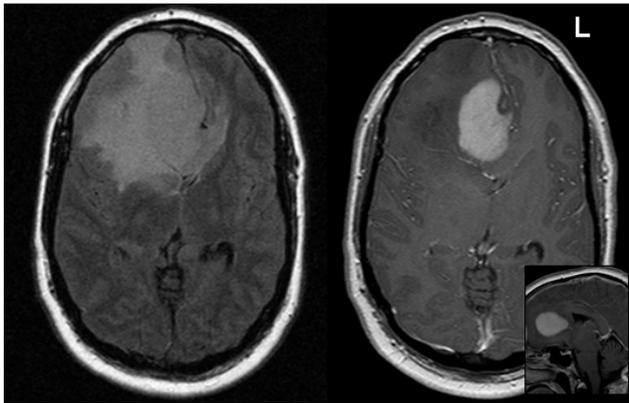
Magnetic resonance imaging scans before medical intervention. Left: FLAIR transverse view revealing signs of perifocal edema. Right: Contrast enhanced T1 weighted transverse view showing the location of tumor and the massive midline shift. Bottom: T1 weighted sagittal view
